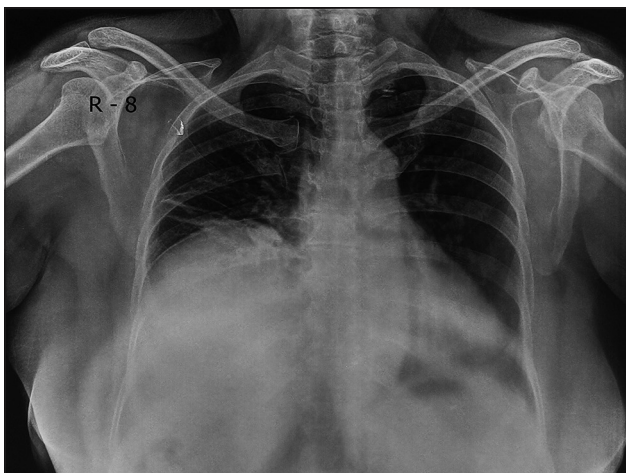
Chest X-ray of the patient showing eventration of right hemidiaphragm
